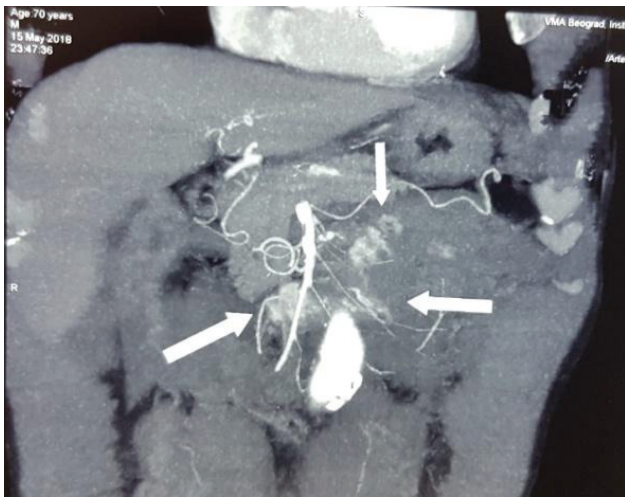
Multislice computed tomography angiography with signs of contrast leakage from wide suprarenal aneurysm to the duodenum and jejunum.
